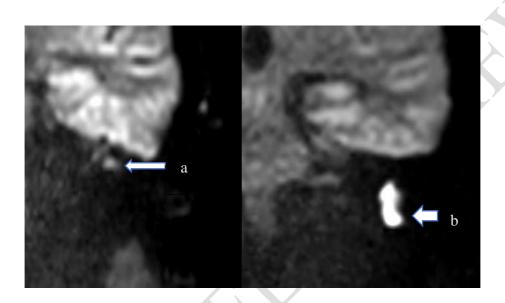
Non-EPI DWI MRI Scan of the temporal bones showing the presence of two cholesteatomas (a-attic and b-mastoid tip) on the left side
